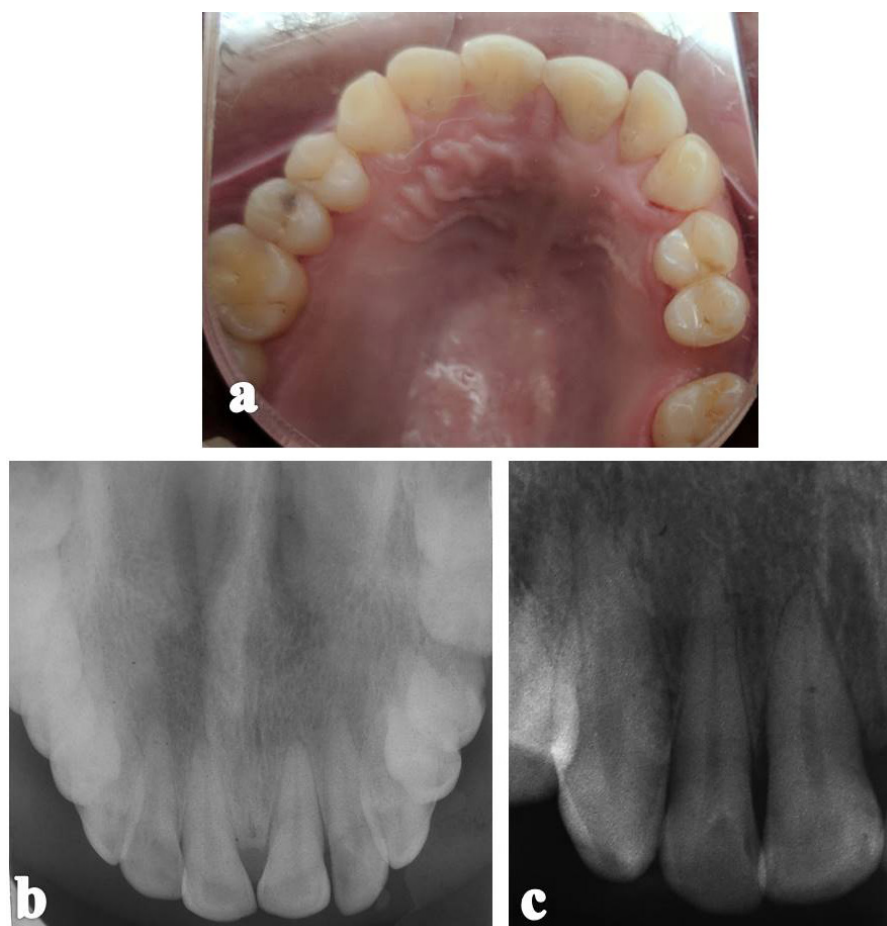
a) Clinical appearance of the biopsy site after one year of biopsy showing clinically indistinguishable appearance of the biopsy site as compared to the adjacent area. b) Maxillary occlusal radiograph showing complete healing with no signs of any recurrence after one year of biopsy. c) Intraoral periapical radiograph after one year of biopsy with good bone healing and no signs of recurrence.
